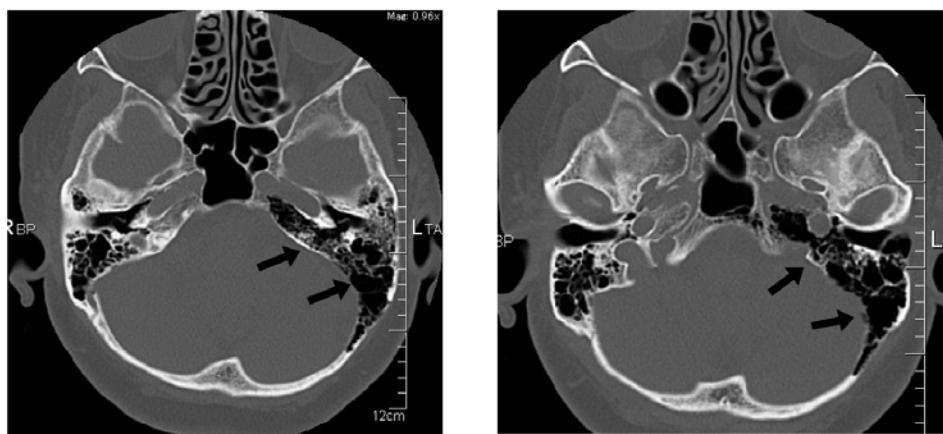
Computed tomography showed the hyperpneumatized left temporal bone extending into the petrous apex (arrows).
